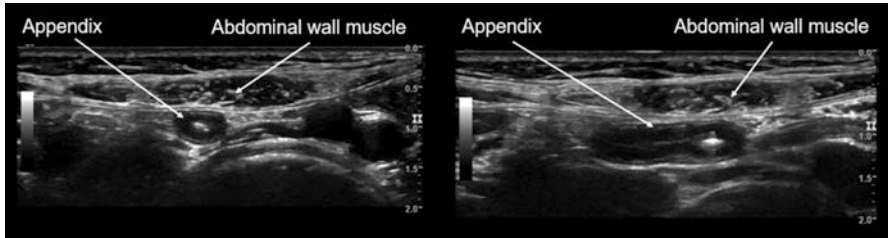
An ultrasound image of a normal appendix. The appendix is an approximately 4 cm projection that arises from the first part of the large intestine known as the cecum. The left panel shows a circular configuration of the appendix indicating this is a short axis (transverse) view of the organ. The right panel shows the appendix as an elongated tubular structure indicating this is a long axis (longitudinal) view of the organ
